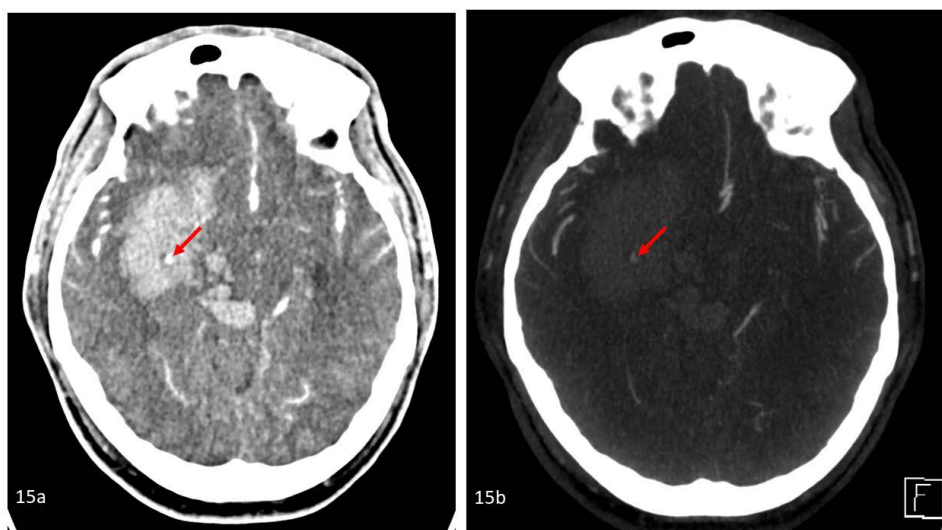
Angiographic positive spot sign. 39 year old male with large intraparenchymal hematoma with signs of active bleed. (15a) CT angiogram of the Circle of Willis with (15b) maximum intensity projection (MIP) show a large acute intraparenchymal hematoma centered in the right basal ganglia and thalamus with intraventricular extension. A subcentimeter area of contrast enhancement within the hematoma is suggestive of a positive angiographic “spot sign” (red arrows), concerning for active hemorrhage. Siemens Somatom Force, Slice width 3.0 mm, 80 kV, 206 mAs; Intravenous contrast: 60 ml Omnipaque 350.
